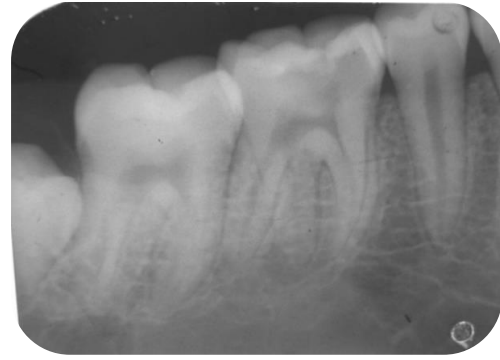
A second preoperative radiograph of tooth 46 taken with a more mesial angulation and revealing the presence of a lingually located additional distal root.
